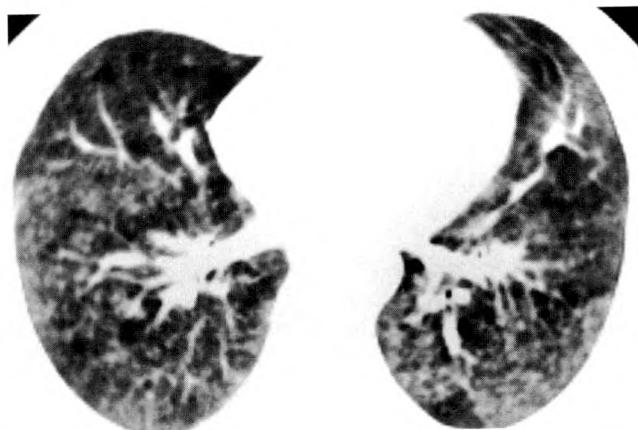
CT scan through lower lobes in patient with extrinsic allergic alveolitis and 6-month history of symptoms. Features of both air-space and interstitial abnormality are present with coalescent finely nodular opacities and thickened linear densities throughout parenchyma.
